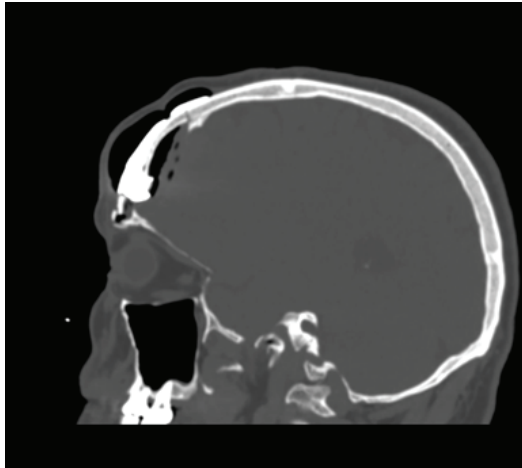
Sagittal reconstruction of brain CT post COVID-19 infection depicting subcutaneous emphysema and pneumocephalus
